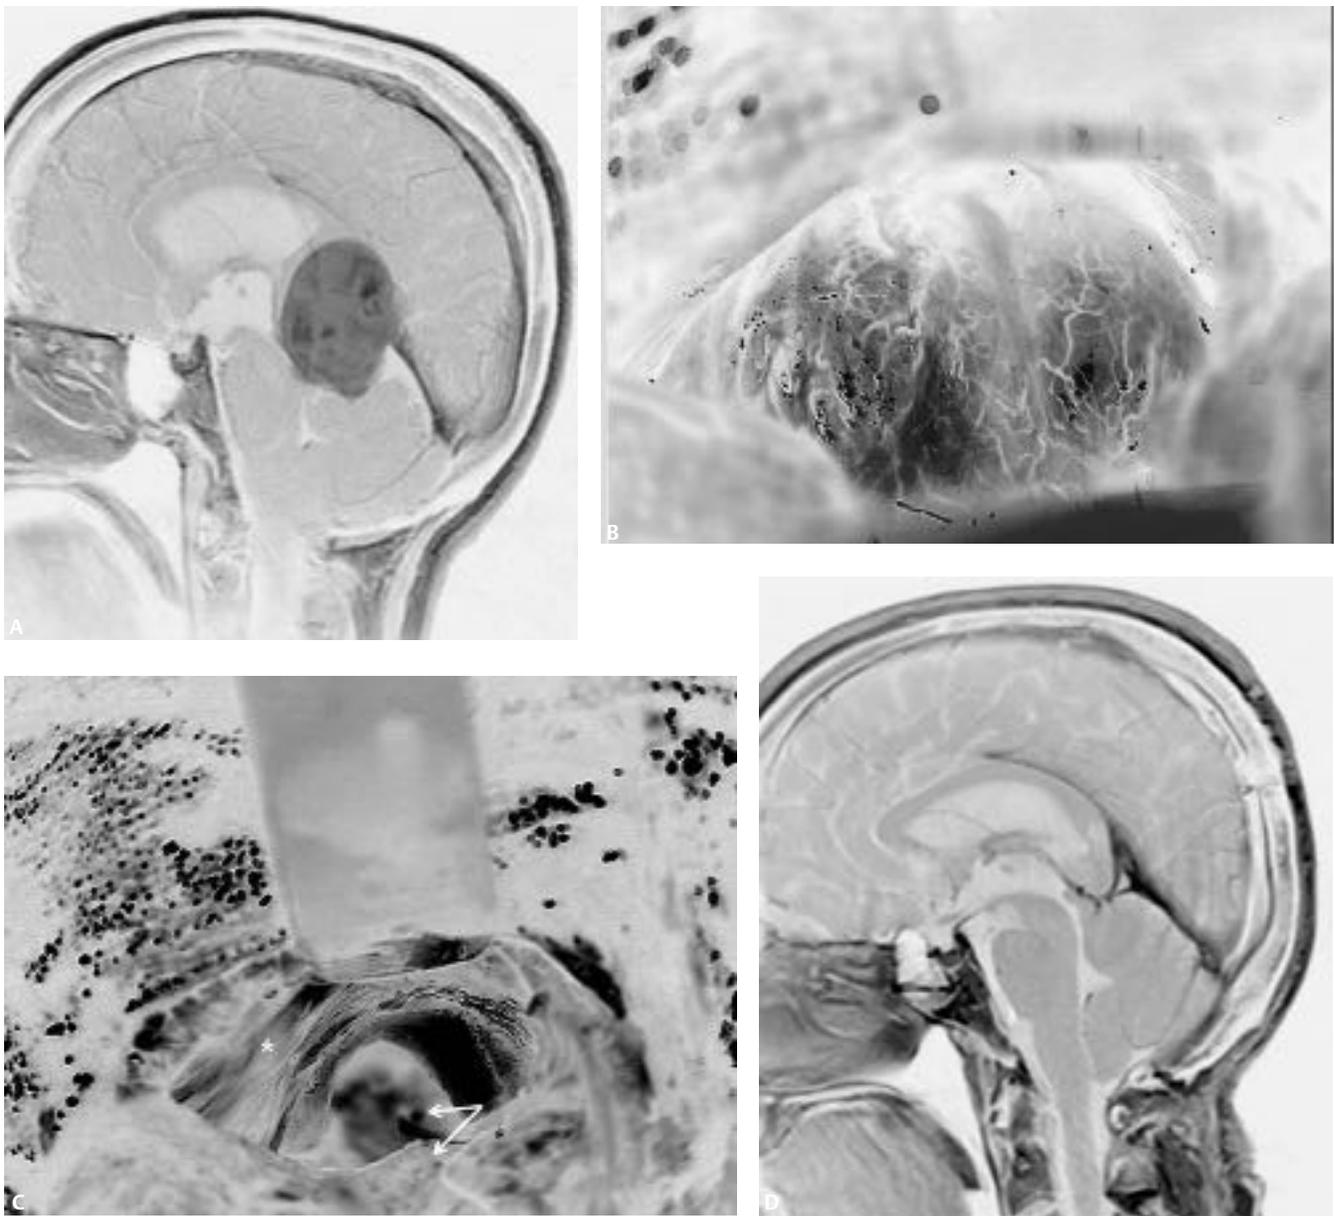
(A) T3–T8 meningioma displayed in preoperative sagittal contrast-enhanced T1-weighted magnetic resonance imaging (MRI) in a patient presenting with gait ataxia and slight mental deficits. Note the patency of the straight sinus and accompanying obstructive hydrocephalus due to occlusion of the aqueduct. (B) An intraoperative photograph shows the tumor as viewed via the supracerebellar infratentorial approach. (C) A second intraoperative photograph reveals the pineal region above the cerebellum (*black arrows*) and below the tentorium (*black asterisk*) after resection of the meningioma. (D) Three months postoperative sagittal contrast-enhanced T1-weighted MRI demonstrates removal of tumor. Note patency of the aqueduct, straight sinus, inferior sagittal sinus, vein of Galen, and internal cerebral veins. Obstructive hydrocephalus and preoperative neurological symptoms resolved.
